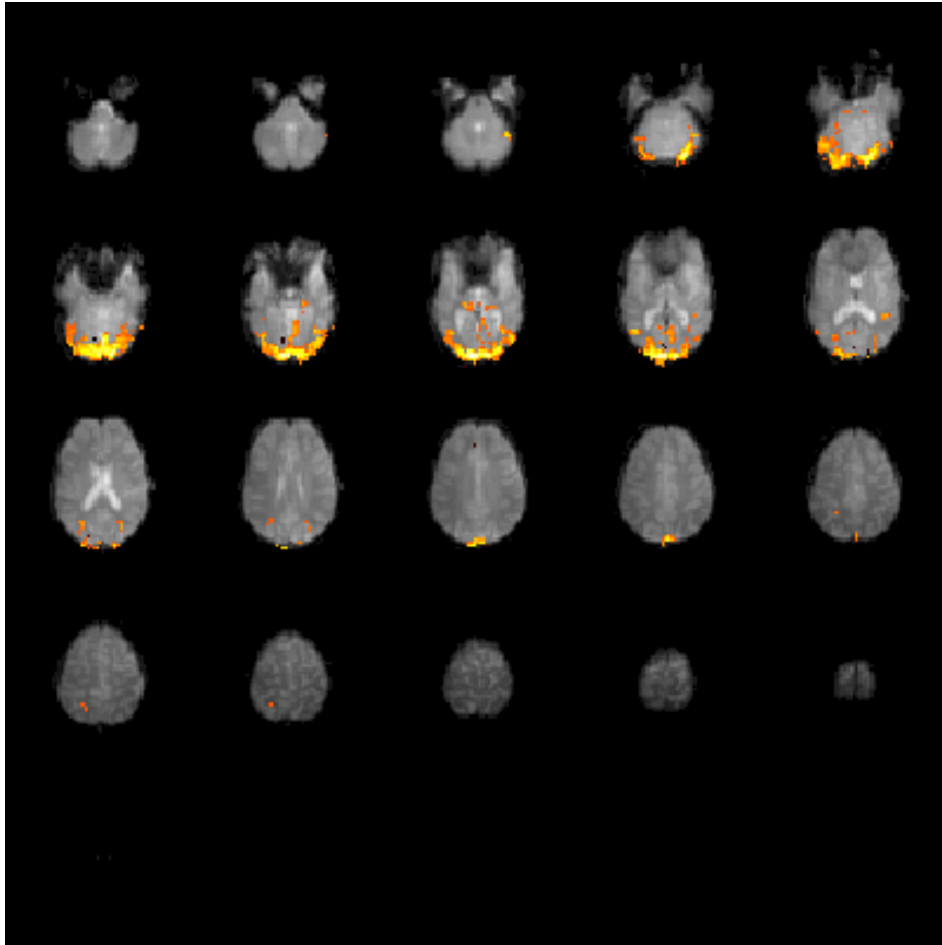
Axial slices of the functional MRI data with with the statistical image overlayed. The test statistics were thresholded at $|Z| \geq 5$.
